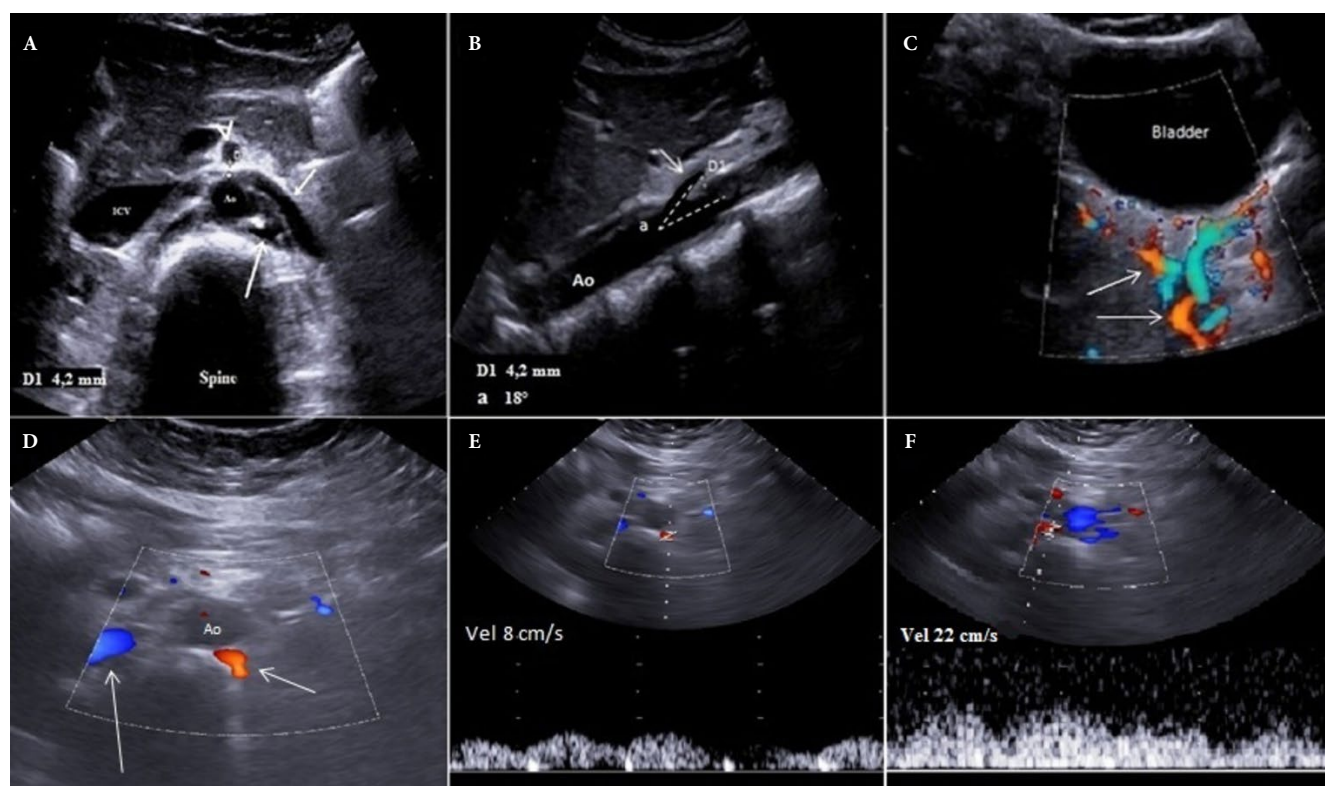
Grayscale US of the abdominal aorta. Measurement of aortomesenteric distance and aortomesenteric angle. A. Transverse scan of the abdominal aorta shows a narrowing of the aortomesenteric space (D1) measuring 4.2 mm. Superior mesenteric artery (arrow head). Left anteroaortic renal vein (short arrow). Left retroaortic renal vein (long arrow). Abdominal aorta (Ao). Inferior cava vein (ICV). B. Longitudinal scan of the abdominal aorta shows a narrowing of the aortomesenteric angle (18°) and aortomesenteric distance (D1) measuring 4.2 mm. C. Pelvic ultrasound scans show gonadal plexus varicosities (arrows). D. Color Doppler US shows prestenotic tract of the retroaortic renal vein (short arrow) and poststenotic tract of the anteroaortic renal vein (long arrow). Ao: Abdominal aorta. E. Duplex Doppler US measure of the prestenotic flow of retroaortic renal vein. F. Duplex Doppler US measure of the poststenotic flow of retroaortic renal vein
